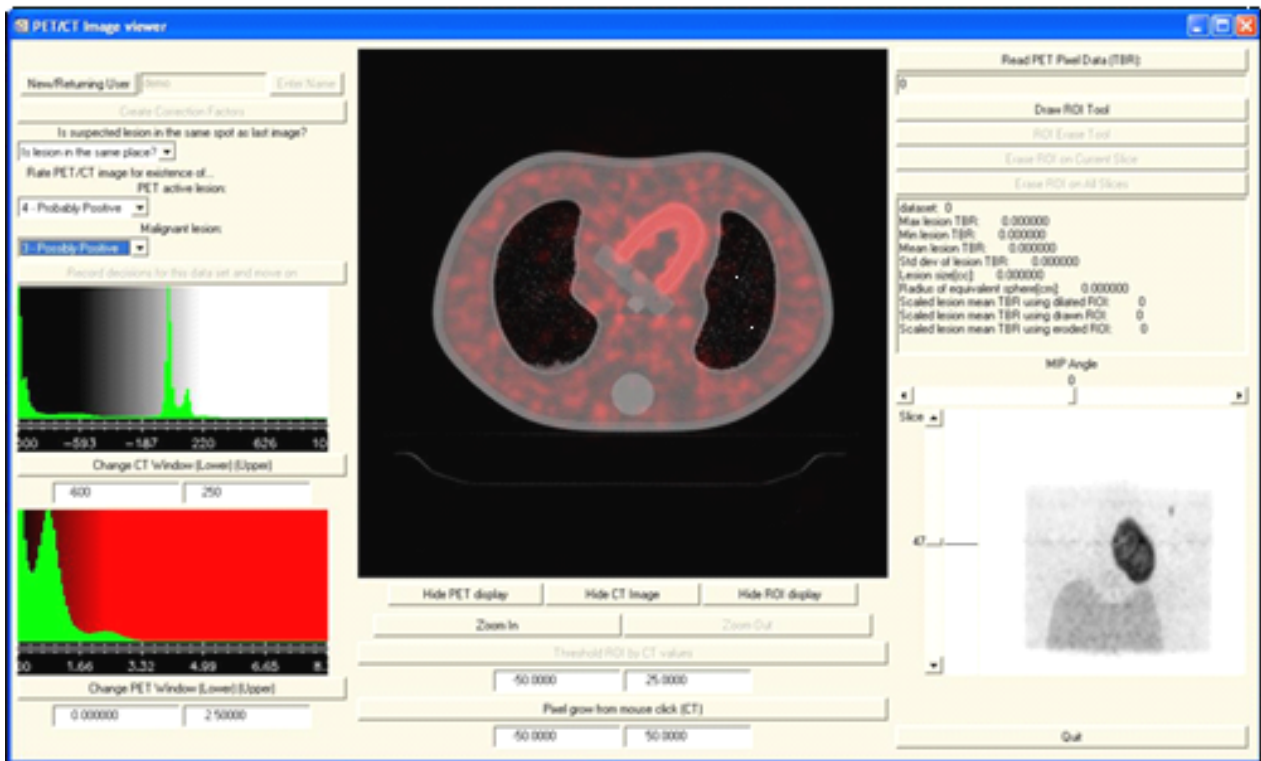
Screen shot of the image presentation software. The user can view and zoom PET, CT and fused PET/CT images, can alter the color table and display windows, and enter rating responses.
